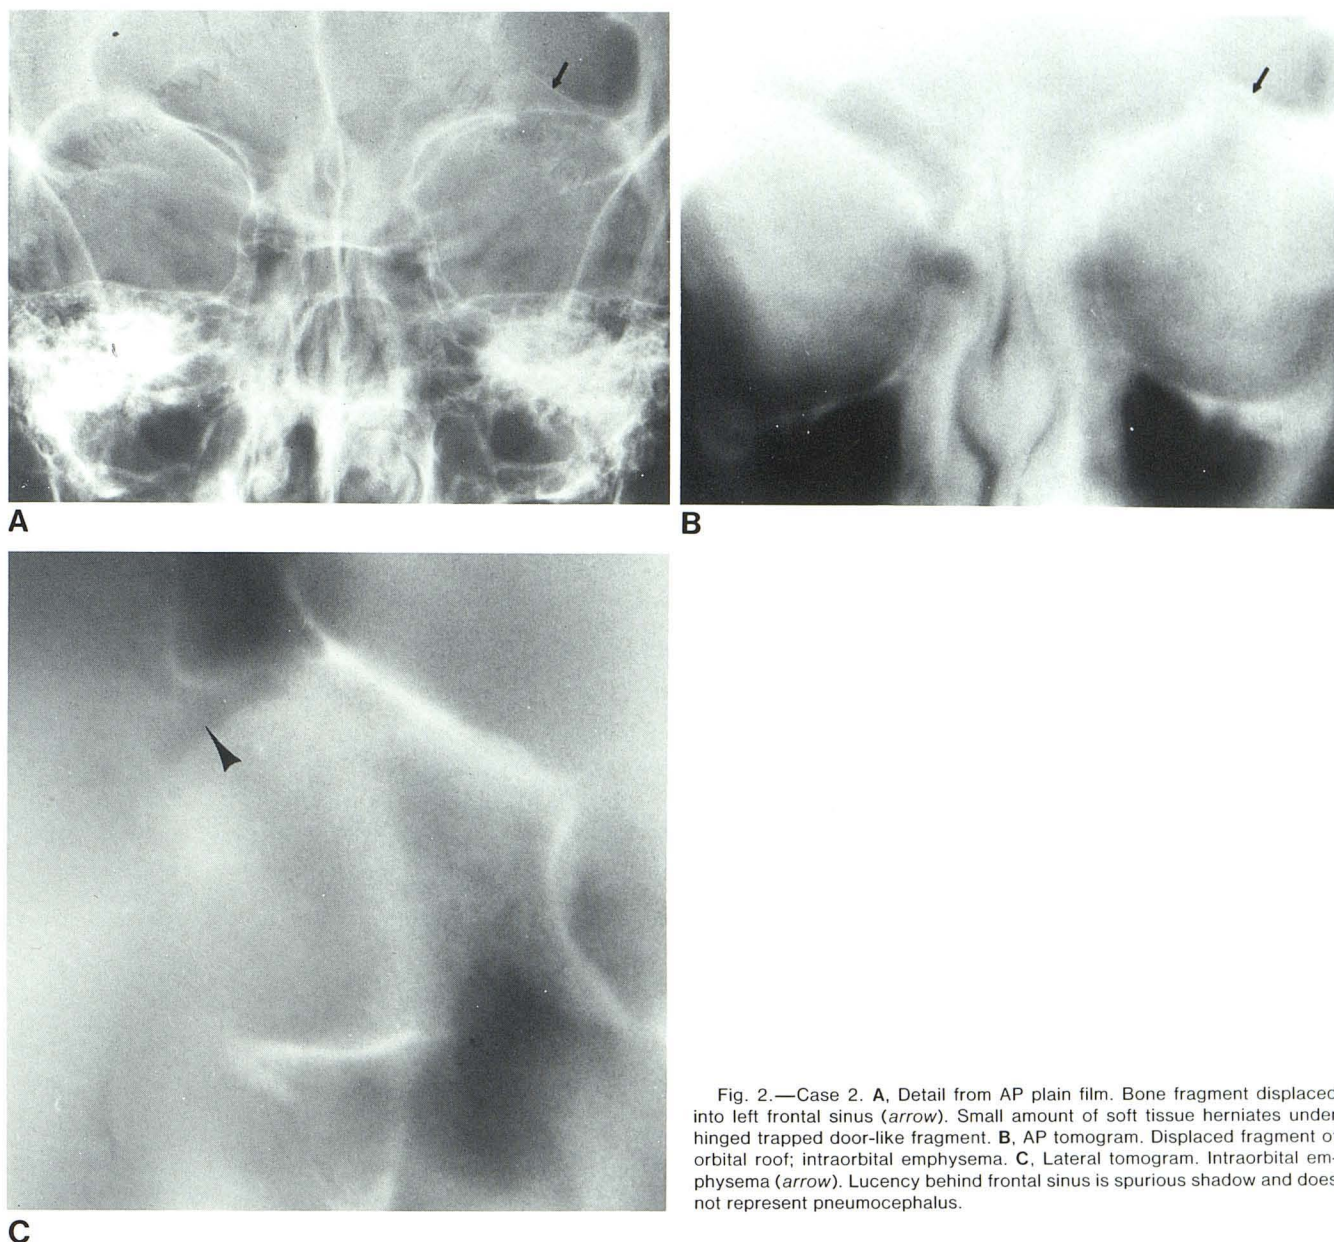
Case 2. A, Detail from AP plain film. Bone fragment displaced into left frontal sinus (*arrow*). Small amount of soft tissue herniates under hinged trapped door-like fragment. B, AP tomogram. Displaced fragment of orbital roof; intraorbital emphysema. C, Lateral tomogram. Intraorbital emphysema (*arrow*). Lucency behind frontal sinus is spurious shadow and does not represent pneumocephalus.
